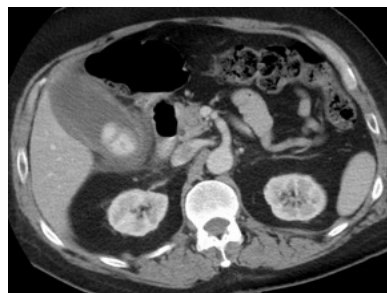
Acute cholecystitis on an axial slice of a CT scan demonstrating a thick gallbladder containing a calcified stone, pericholecystic fluid and fat stranding indicative of surrounding inflammation.
